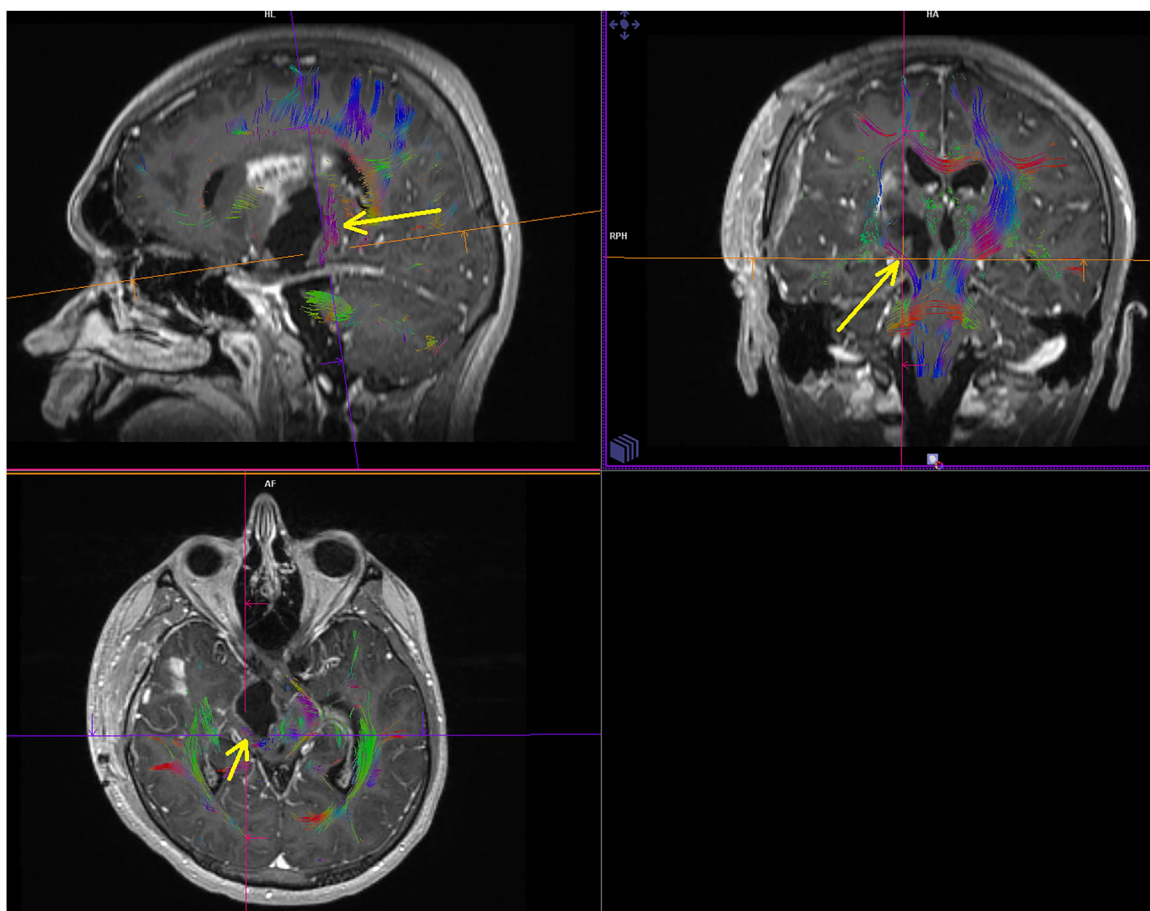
Postoperative magnetic resonance images of a patient. Total tumor resection. The internal capsule is spared. The patient presented with postoperative paresis grade I (NIHSS).
